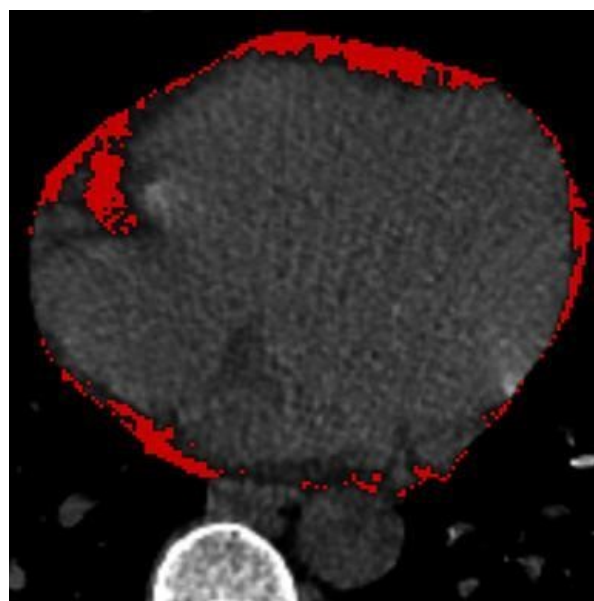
The measurement of EAT volume by non-contrast CT. Abbreviations: CT, computed tomography; EAT, epicardial adipose tissue.
